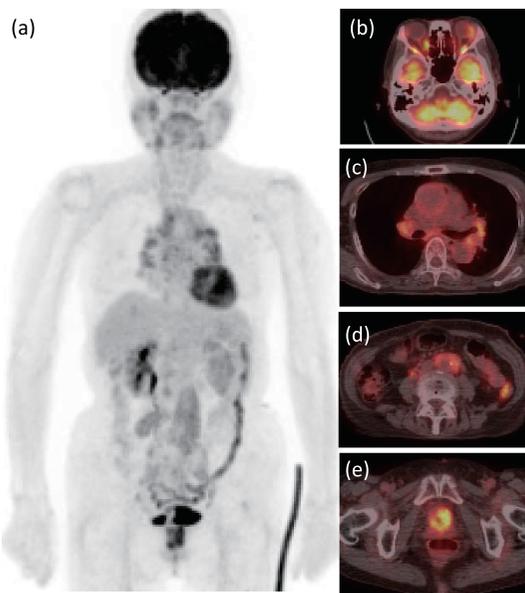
The FDG-PET findings in a patient with IgG4-related periurethral lesion.
